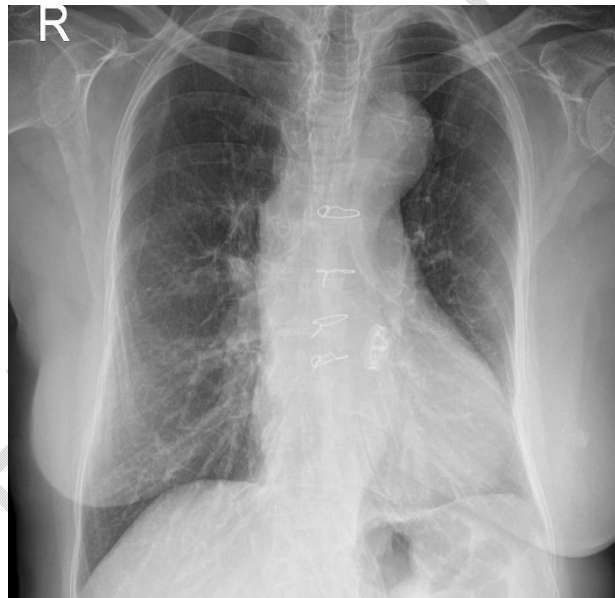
Follow up Chest X-ray was done after 10 days of discharge and it shows a normal radiographic imaging
